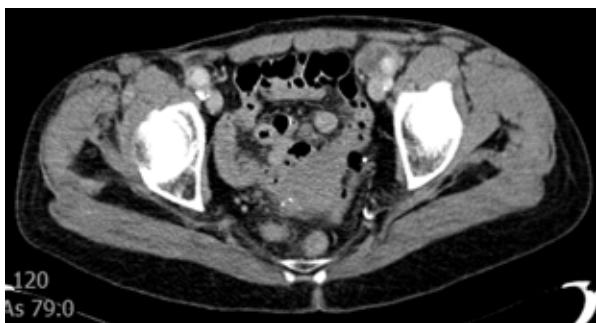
CT – Perigraft fluid, yellow arrow.
